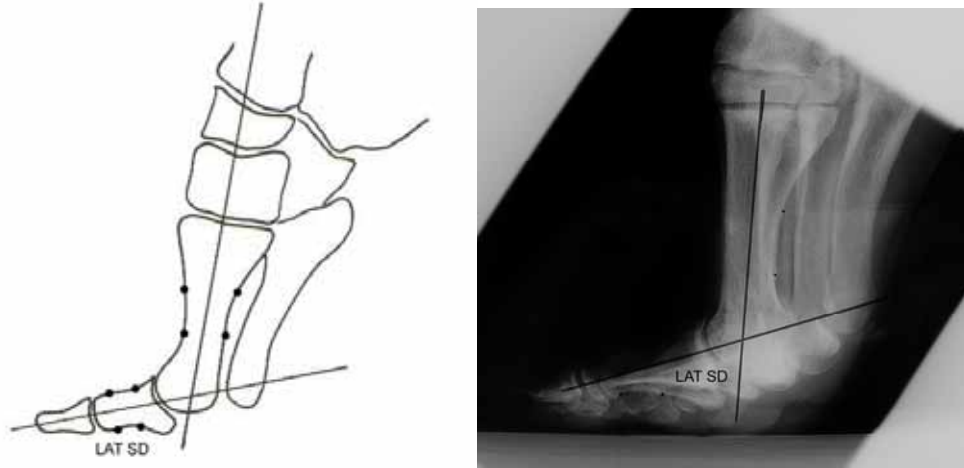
Measurement of weight bearing first MPJ dorsiflexion using a weight bearing LAT SD radiograph (adapted from Taranto et al, 2004)⁷
